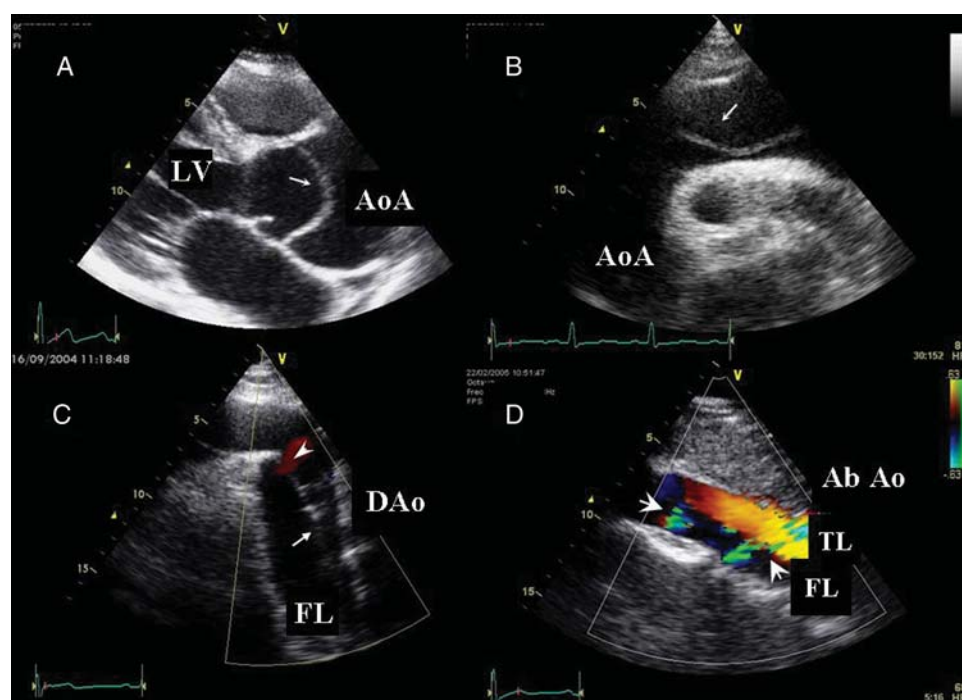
Aortic dissection diagnosis by transthoracic echocardiography. Intimal flap (arrows) and two lumina are visualized in: (A) aortic root, (B) aortic arch and distal ascending aorta, (C) proximal descending aorta (arrowhead shows the entry tear), and (D) dissection of abdominal aorta. Colour Doppler helps to identify the true lumen (TL). Arrowheads signal secondary communications.
